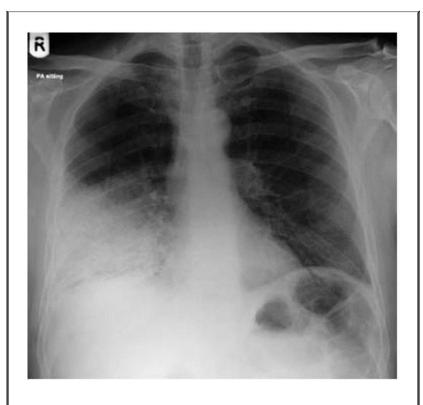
Radiograph showing right lower lobe consolidation.
